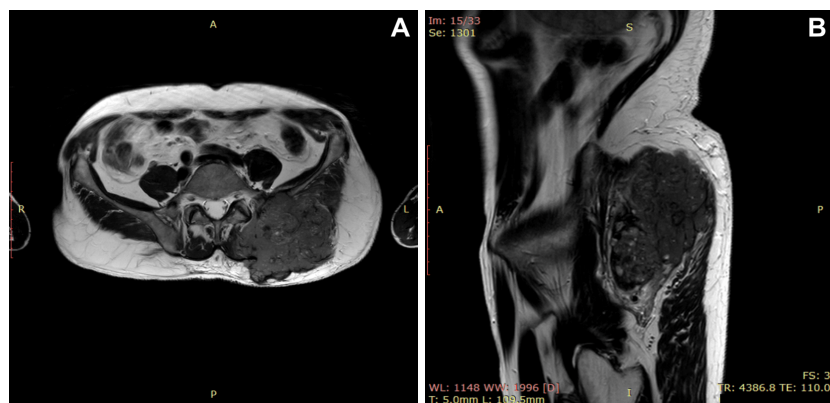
MRI of the left gluteal mass, showing an inhomogeneous, intensely gadophilic mass, displaying edema and osteolysis of the sacrum and iliac crest, with invasion of soft parts and paravertebral and gluteal muscles: (A) Cross-sectional image; (B) Sagittal view.
